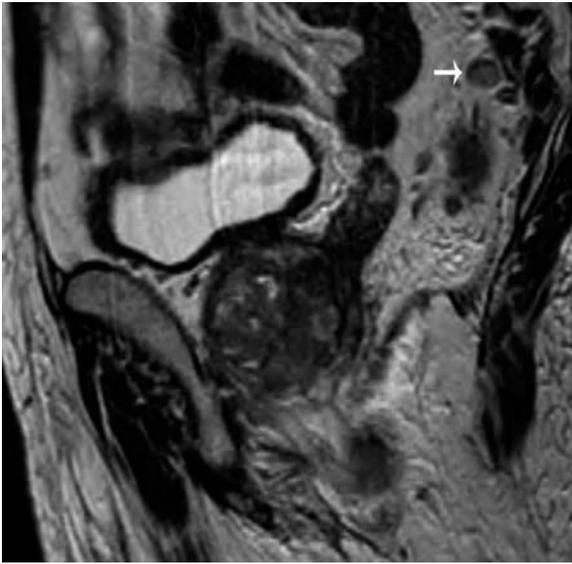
62-year-old female with stage T3 rectal carcinoma. Sagittal T2-weighted image reveals a prominent, ovoid, 7-mm presacral lymph node (arrow).
